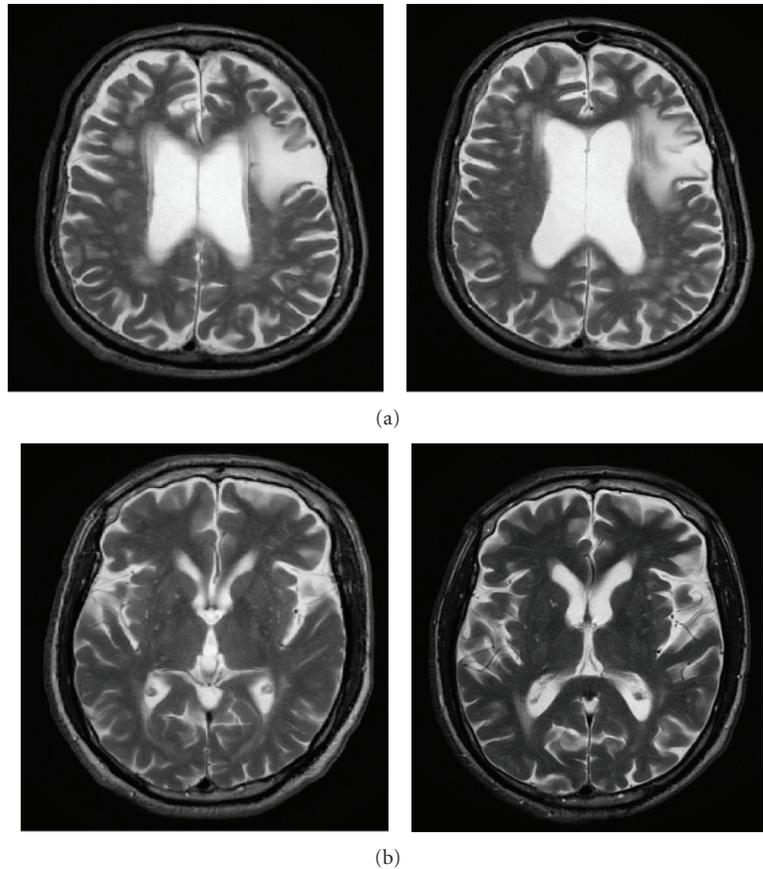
Shows T2 FLAIR axial images. (a) Depicts bilateral asymmetric multifocal hyperintensities involving pontine base periventricular and deep white matter suggestive of small-vessel ischemia. Diffuse brain atrophy is also seen with mineralization below globus pallidus and substantia nigra indicative of PD. There is no significant difference noted between the baseline and follow-up MRI. (b) Depicts moderate brain atrophy with bilateral putaminal rim sign seen. Small-vessel ischemic changes are seen in the bilateral periventricular and deep white matter. Mineralization of bilateral lentiform nuclei, dentate nuclei, and substantia nigra visualized is suggestive of MSA-P or PD plus syndrome. There was no significant difference noted between the baseline and follow-up MRI.
